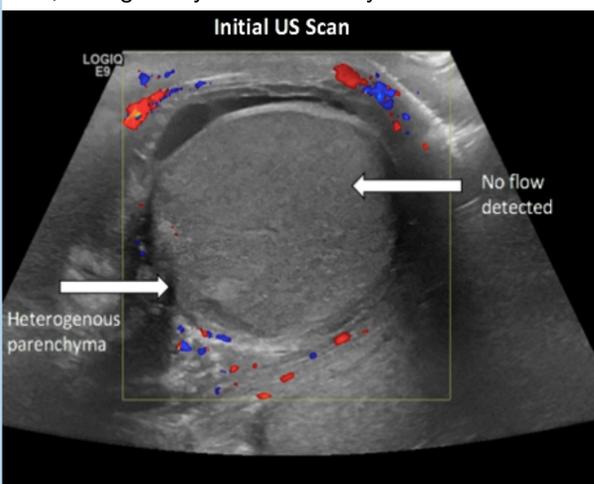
Transverse view demonstrating an enlarged and mildly heterogenous right testicle in keeping with common US appearances of epididymo-orchitis (Suciu *et al.* 2017). An increase in vascular uptake on colour Doppler assessment is expected in early stages of epididymo-orchitis (Suciu *et al.* 2017). However, intra-testicular flow is not detected on colour Doppler assessment, concerning for testicular torsion or infarct due to chronic infection (Cek *et al.* 2017).
